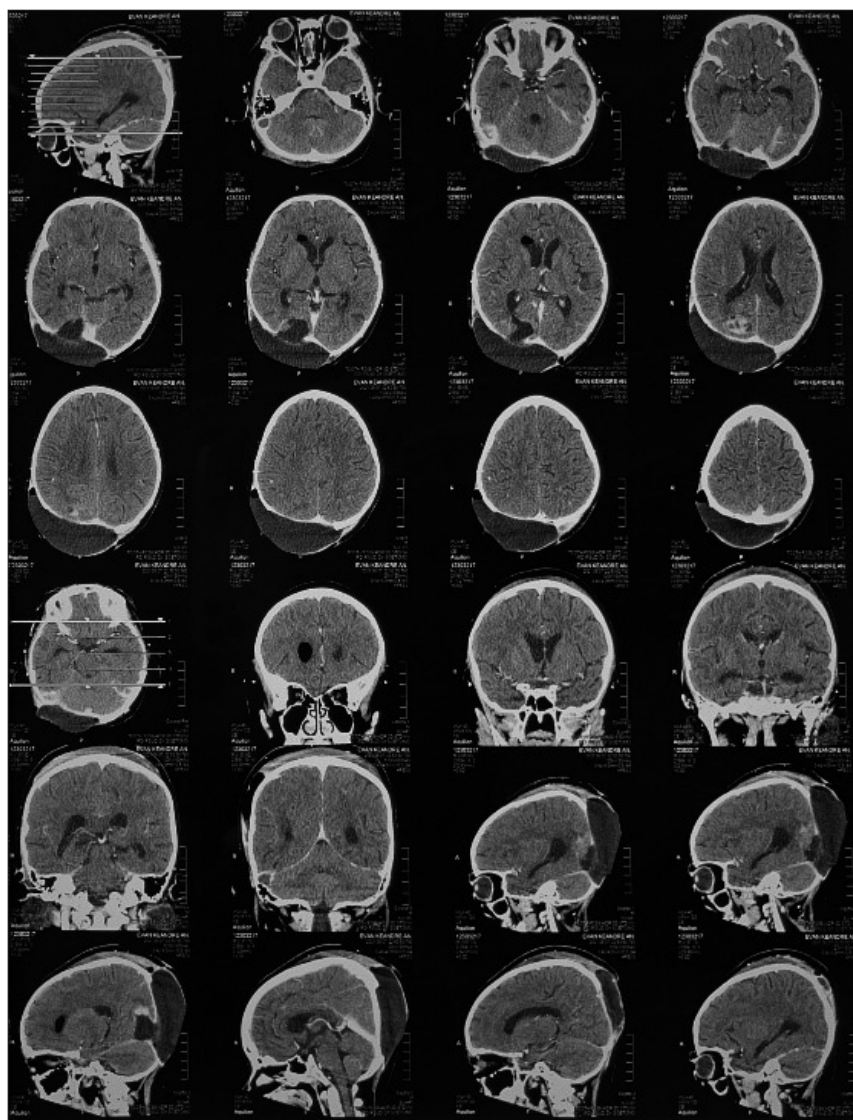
Head CT-scan with contrast demonstrating subgalea effusion and connection between the tumor bed and the ventricular system
